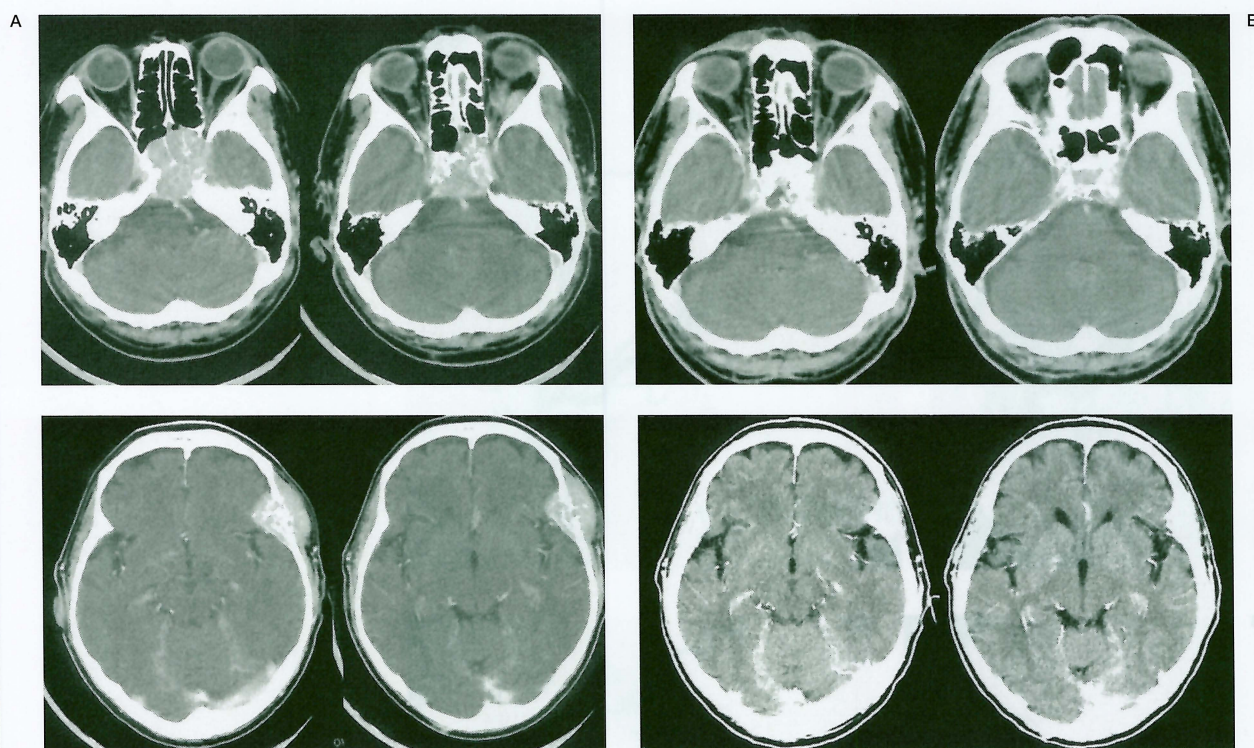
Case 3: Flow-controlled injection. A 61 year-old man with skull base metastasis from hepatocellular carcinoma. A) Initial contrast enhanced CT scans demonstrating enhanced mass lesions involving sphenoid sinus and left temporal bone with bone destruction. B) Contrast enhanced CT scans obtained 1 year after 4 sessions of flow controlled injection of CDDP. No evidence of residual tumor was shown.
